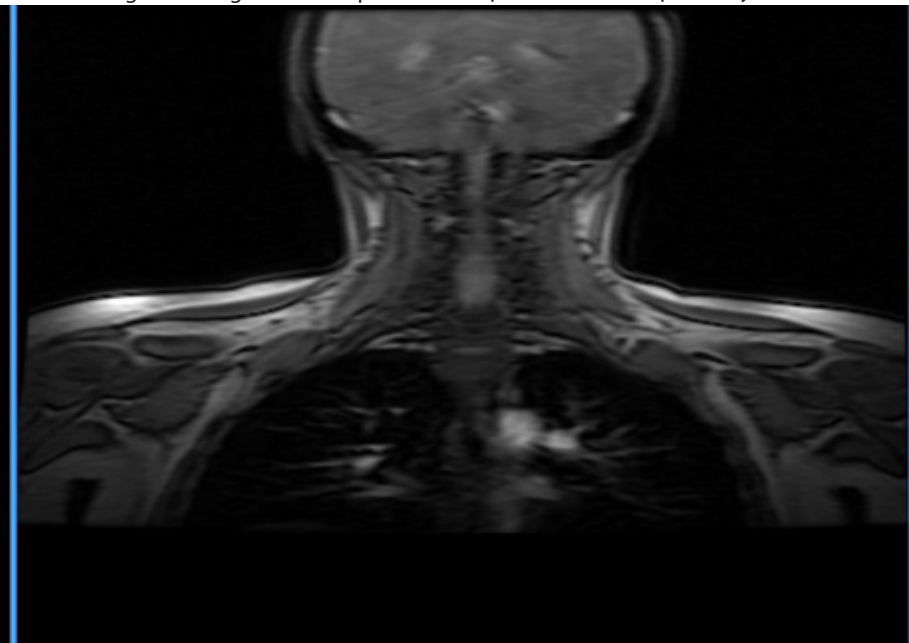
Magnetic resonance imaging done shows lesions in the Cervical part (C spine 3 – pl loc).
